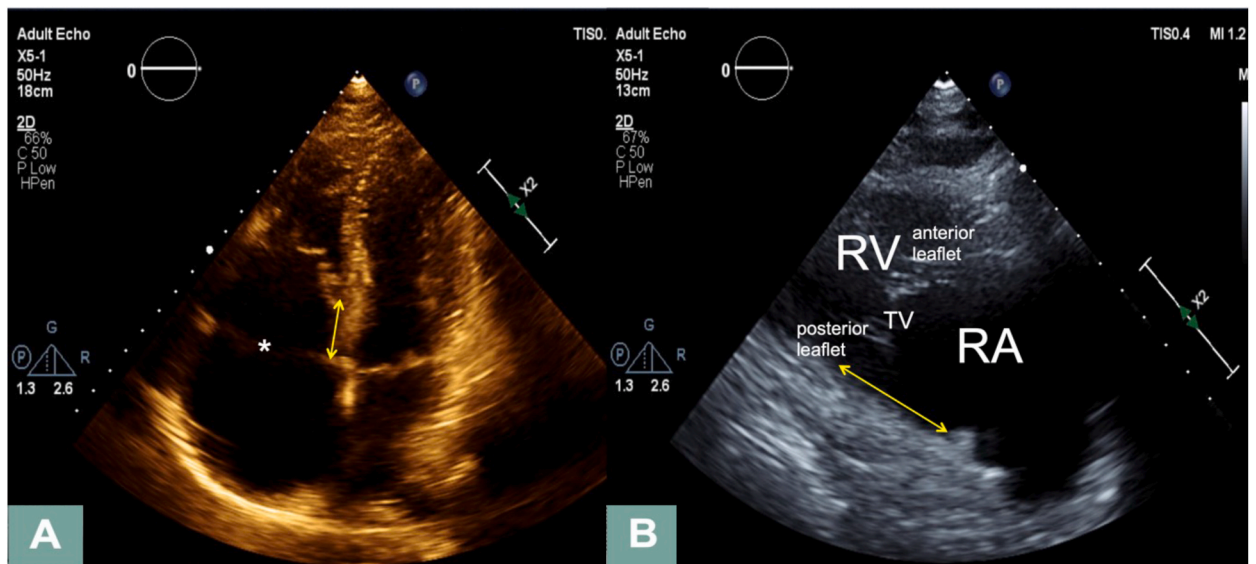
Patient's Echocardiogram. Panel A: four-chamber view with typical findings of Ebstein anomaly with right atrial (RA) dilation and right ventricular (RV) atrialization (asterisk) of the tricuspid valve (TV) relative to the mitral annulus (double arrows). Panel B: RV inflow view demonstrating apical TV displacement (double arrows).
